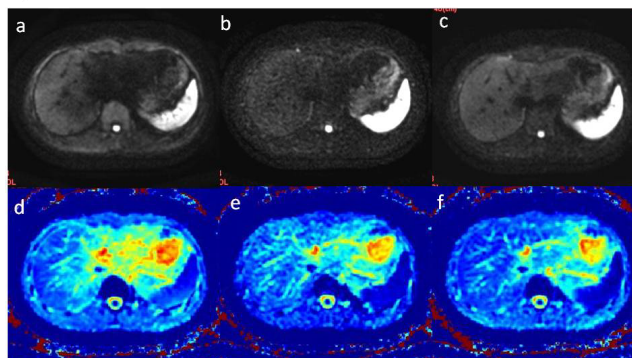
DWIs (a-c), and ADC maps (d-f) acquired with c-DWI (a, d), VC-DWI (b, e), and t-VC-DWI (c, f).
